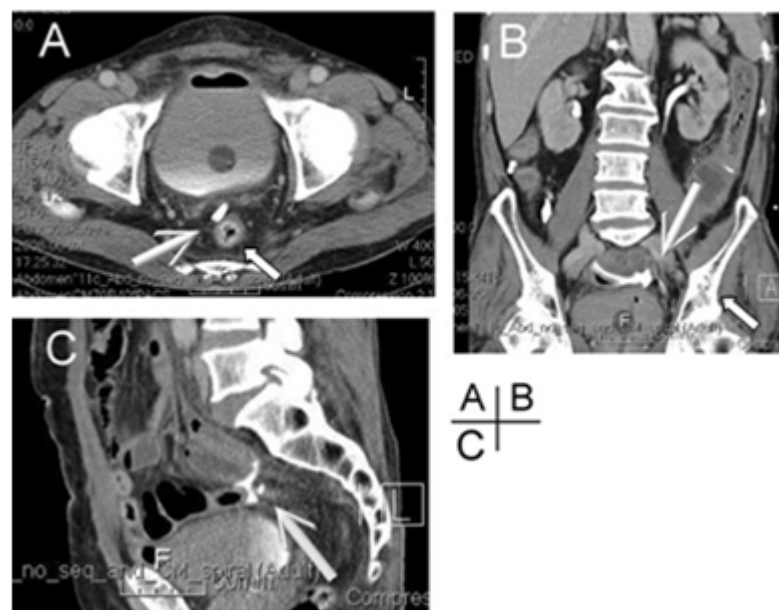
Computed tomography with transverse (A), coronal (B), and sagittal (C) views of the pelvis showing contrast medium extravasation from the urinary system into lower peritoneal cavity (arrow)
